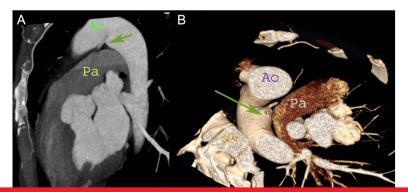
Contrast-enhanced cardiac computed tomographic sagittal maximum intensity projection (MIP) view showing the ductus diverticulum (arrow) (A), contrast-enhanced caudocranial volume-rendered (VR) image showing the ductus diverticulum (arrow) (B). Ao, aorta; Pa, pulmonary artery.
